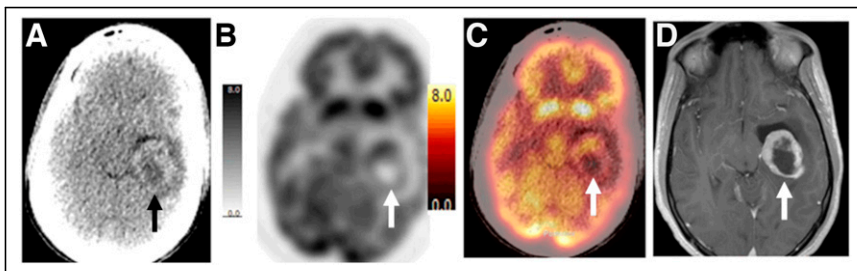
A 23-y-old man with progressive metastatic osteosarcoma: attenuation-correction CT image (A), PET emission image (B), PET/CT image (C), and axial T1 MR image (D). ^{18}F -FDG PET/CT shows previously unknown left temporal lobe metastasis (arrows) (SUV_{max} , 6.4). There is uptake at periphery of lesion, with reduced uptake centrally, consistent with necrosis. Contrast-enhanced T1 MR image obtained following day shows irregularly rimmed ring enhancing lesion in left temporal lobe, consistent with metastatic disease.
